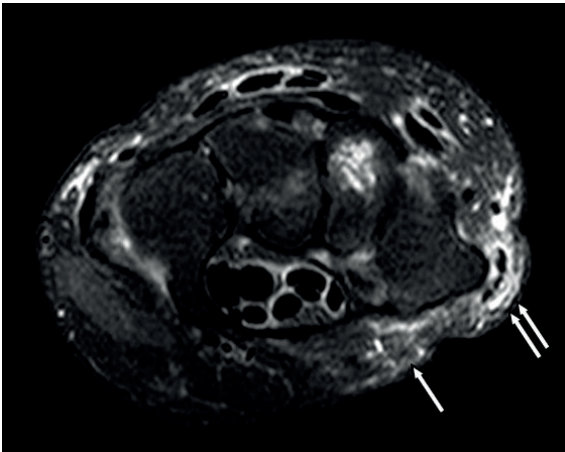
Soft tissue edema in mixed connective tissue disease in a 13 year old girl. Axial T2-weighted image (A) visualizing infiltration of the subcutaneous fat (high signal intensity), possibly indicative of active sclerosis. Also bone marrow edema in the trapezoid and tenosynovitis (enhancement on T1 after contrast administration, B) in both the flexor- and extensor-compartments are present
